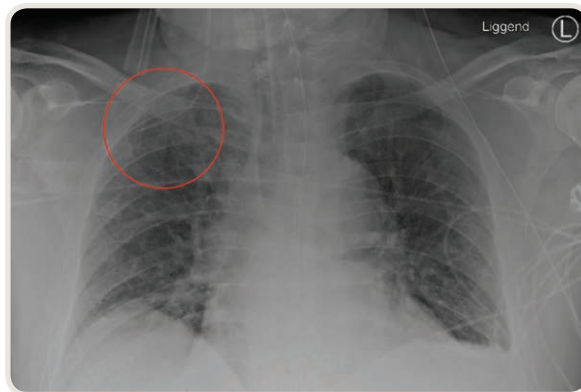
A chest x-ray film of a patient with a central venous catheter malpositioned in the right subclavian vein. The red circle denotes the malposition.
